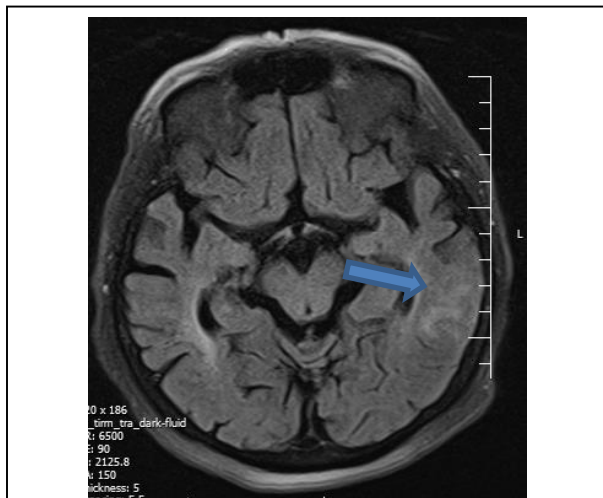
Brain MRI showing abnormal cortical and subcortical hyper-intense signal in the left temporal lobe with the foci of hyper-intense signal suggesting hemorrhagic venous infarction
